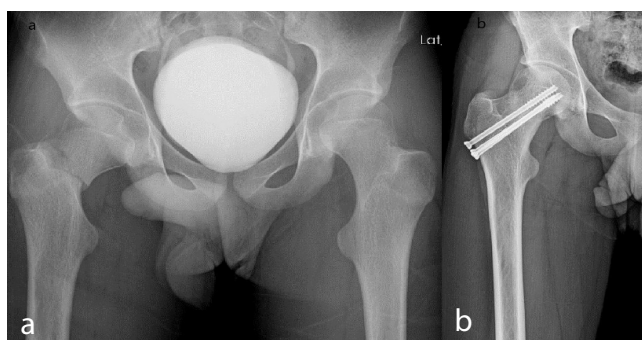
Preoperative (a) and postoperative second-year (b) radiography of a male patient with a femoral neck fracture
